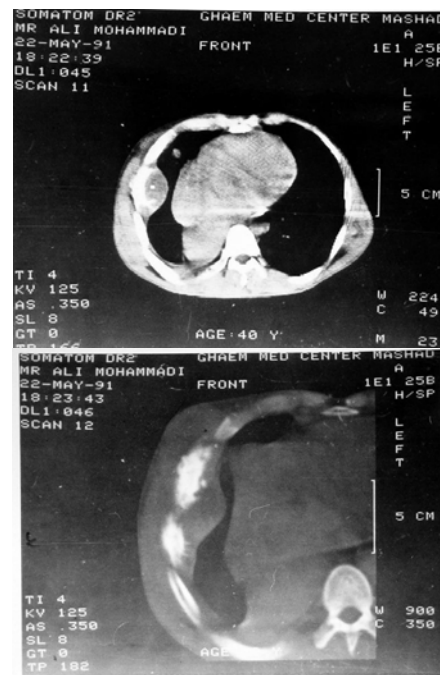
(a, b)-Case 5: Axial CT scan demonstrate lytic- sclerotic metastasis of the ribs and associated soft-tissue mass.
